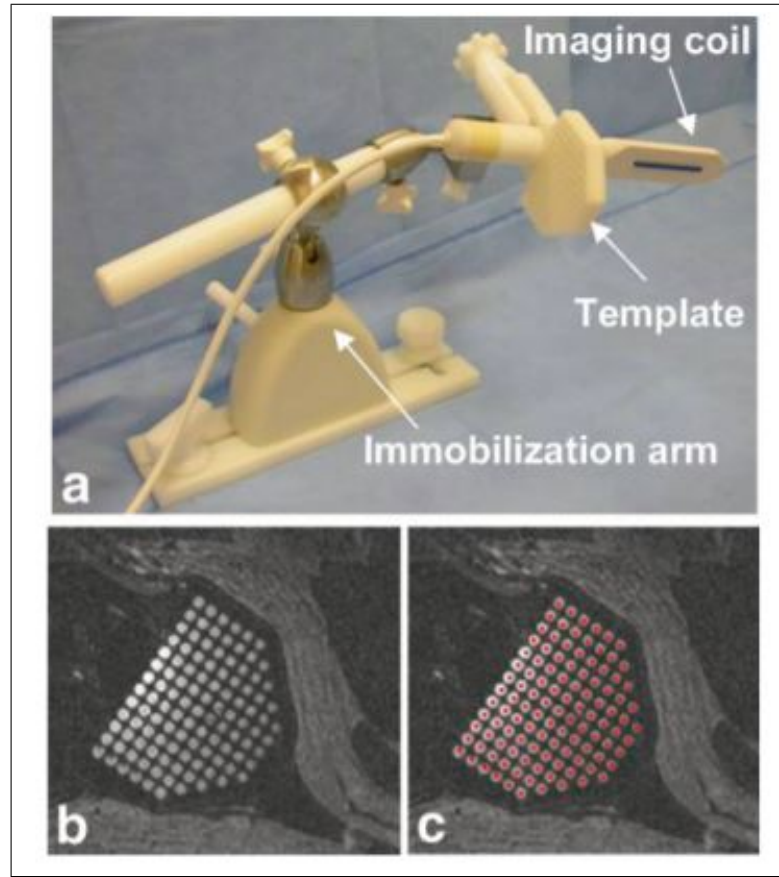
Needle placement device. a) The needle-guiding template and endorectal imaging coil. b) The template holes, filled with surgical lubricant, are easily visualized in MR images. c) After registration of the position and orientation of the needle-guiding template. Visualization of the template allows for easy verification of this registration. [3]
